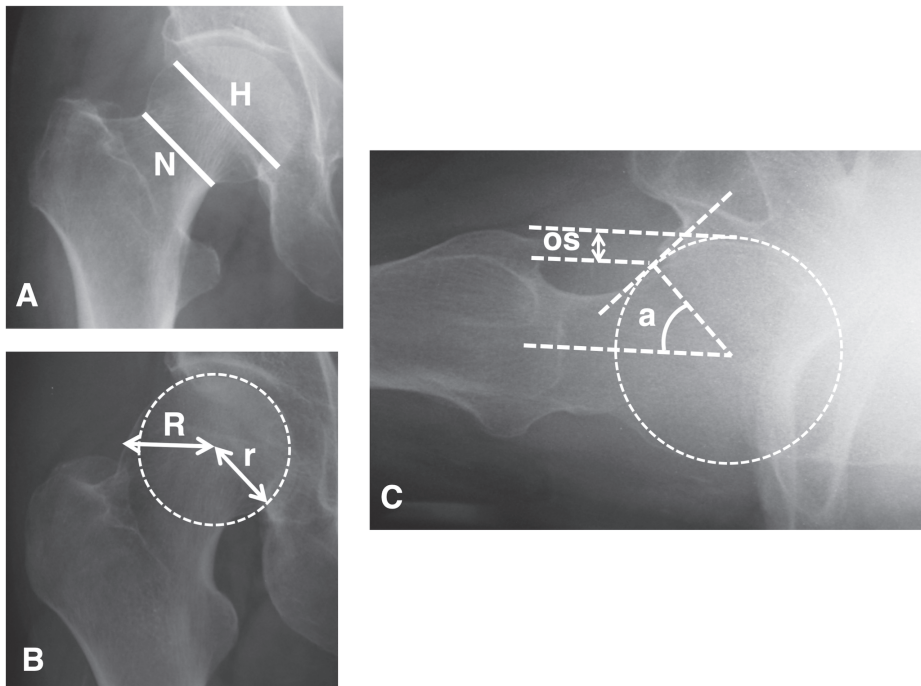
A typical radiological assessment. A, The femoral head-neck ratio on an anteroposterior pelvic radiograph, defined as the ratio of the maximal femoral head diameter (H) divided by the minimum parallel femoral neck diameter (N); B, A positive pistol-grip deformity on an anteroposterior pelvic radiograph, identified by calculating the triangular index, which is considered pathological when the R is $\geq (r+2 \text{ mm})$; C, The alpha angle (a) on a cross-table axial radiograph, defined as the angle between the femoral neck axis and the line connecting the head center with the starting point of asphericity of the head-neck contour. The femoral head-neck offset (OS) was defined as the difference in the radius between the anterior femoral head and the anterior femoral neck.
